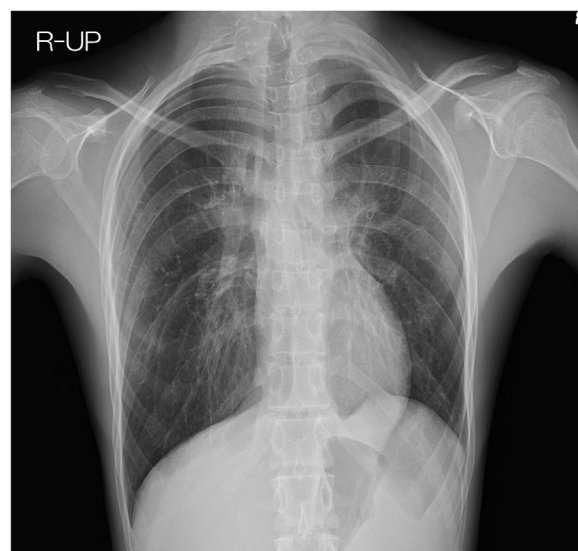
Plain radiograph reveals fusion from C4 to Th2 with right to convex scoliosis and a hypoplastic right second rib.
